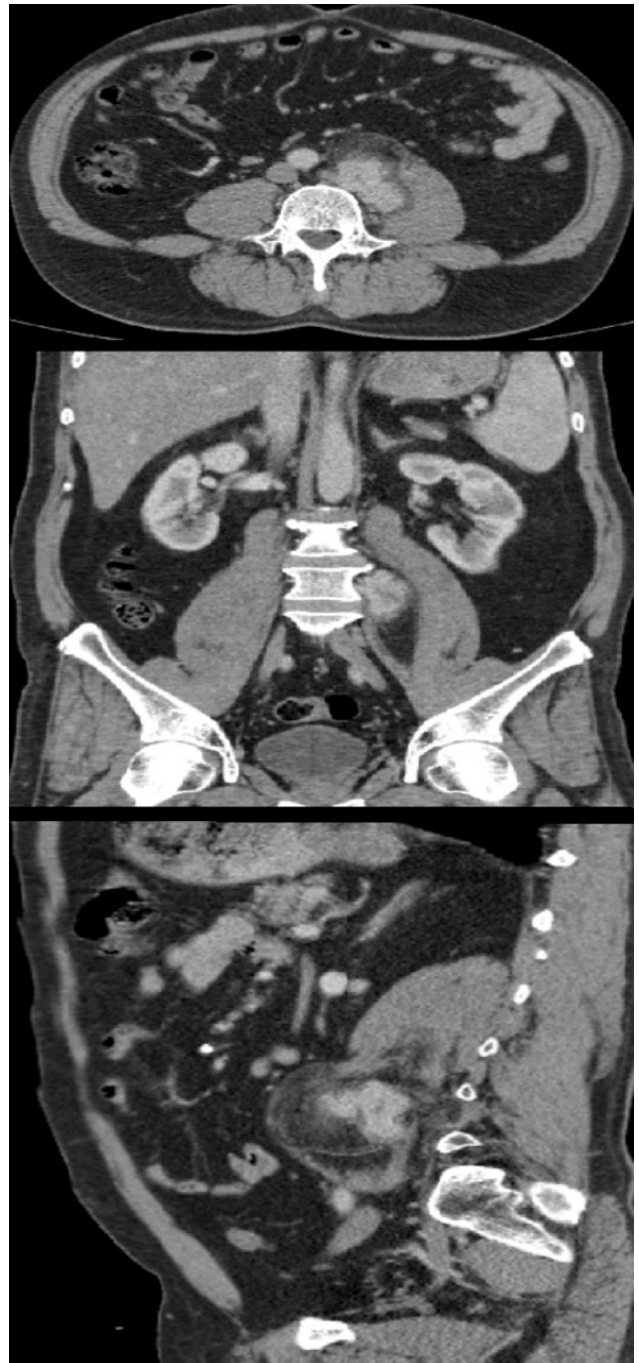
Computed tomography (CT) image demonstrating the identified lesion.
